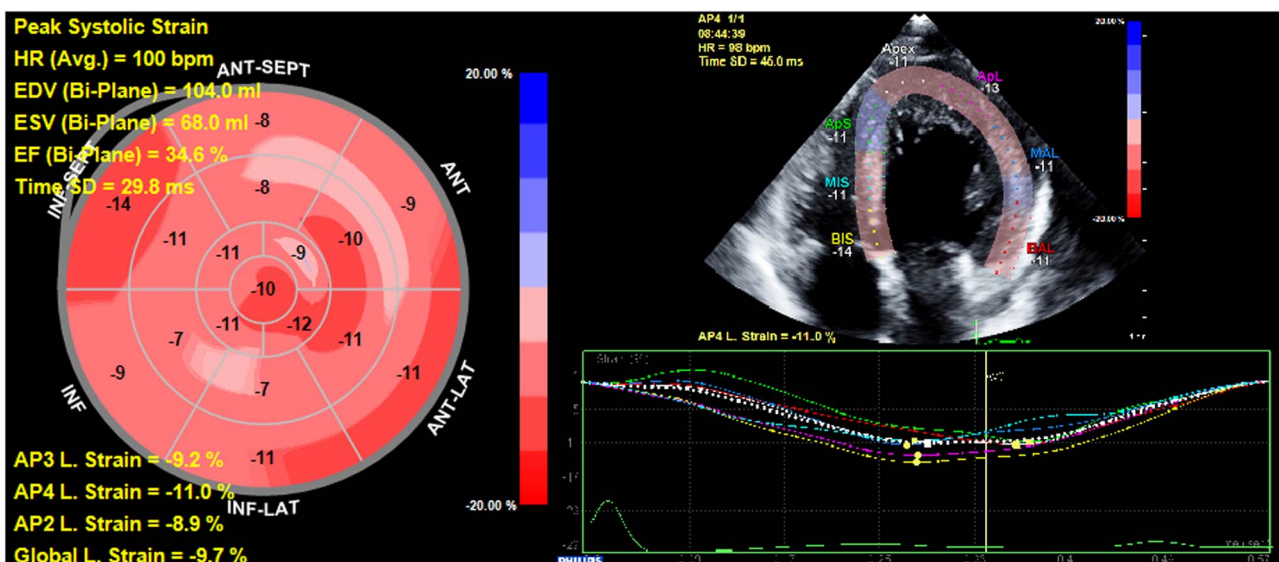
Two-dimensional speckle tracking echocardiography reveals harmonised myocardial deformation after surgery in patient 5 (Epiq 7G, QLab 10.4, aCMQ module). ANT=anterior; AP2=apical two chamber view; AP3=apical three chamber view; AP4=apical four chamber view; APs=apicoseptal; APl=apicolateral; BAL=basal anterolateral; BIS=basal inferoseptal; EDV=enddiastolic volume; ESV=endsystolic volume; EF=ejection fraction; HR=heart rate; INF=inferior; LAT=lateral; MAL=mid anterolateral; MIS=mid inferoseptal; SEPT=septal.
